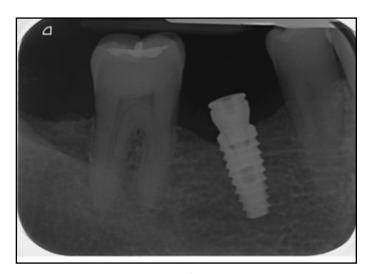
Radiograph taken after the implant placement.
